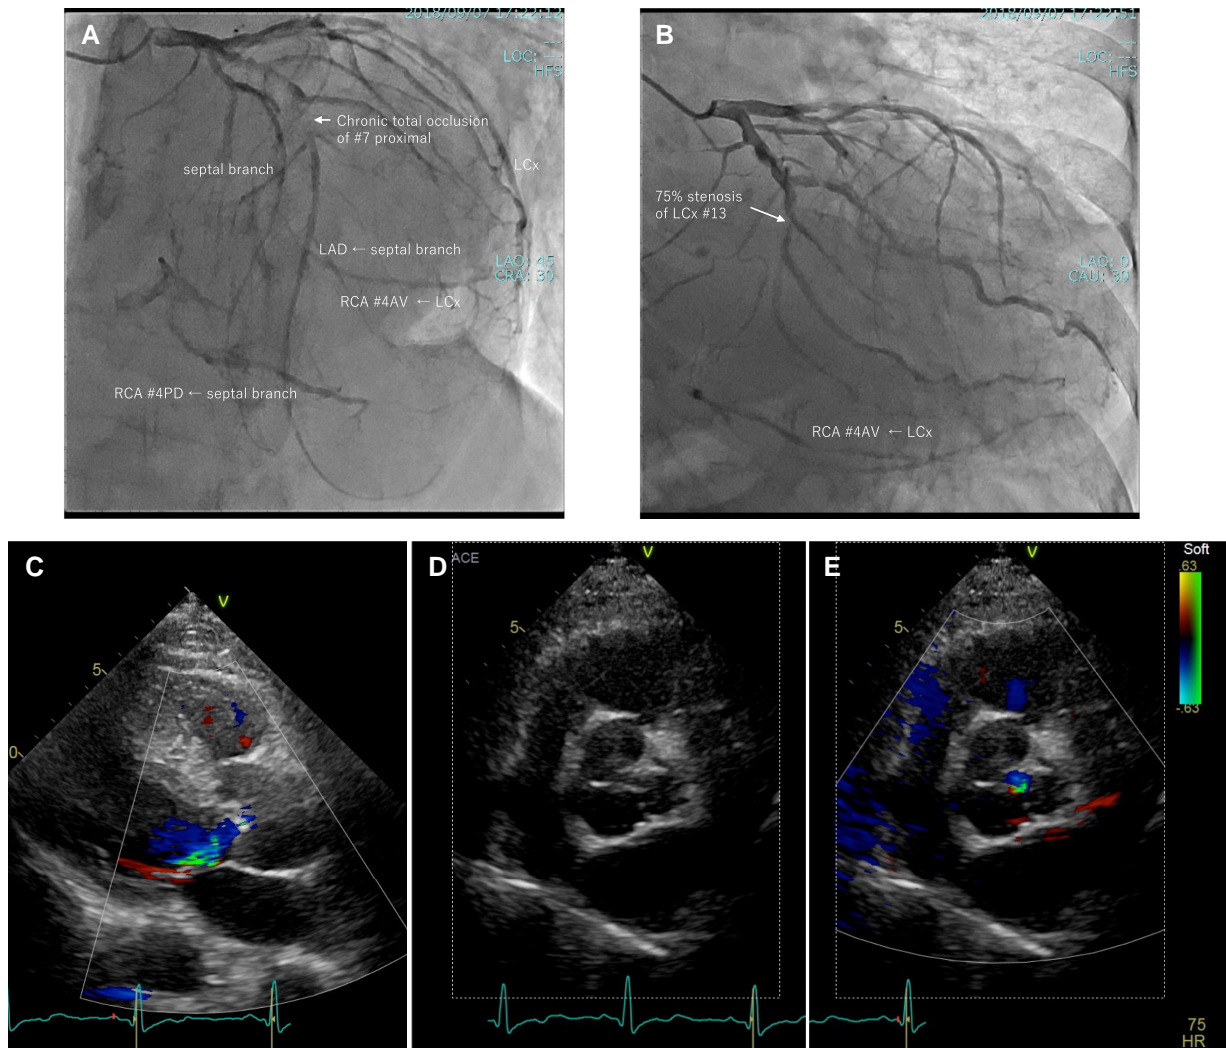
(A, B) Pre-operative coronary angiography. (A) Left anterior oblique 45°, cranial 30°; chronic total occlusion of the proximal left anterior descending artery (#7) and right coronary artery (#1). The right coronary artery #4PD and left anterior descending artery were supplied by collateral circulation from the septal branch, while the right coronary artery #4AV was supplied by collateral circulation from the left circumflex branch. (B) Left anterior oblique 0°, caudal 30°; 75% stenosis of the left circumflex artery (#13). (C–D) Pre-operative trans-thoracic echocardiography. (C) Trivial aortic regurgitation in a parasternal longitudinal view. (D) A probable trileaflet aortic valve. (E) Trivial aortic regurgitation in a short axis view. AV, atrioventricular node artery; LAD, left anterior descending artery; LAO, left anterior oblique; LCx, left circumflex artery; PD, posterior descending artery; RCA right coronary artery.
